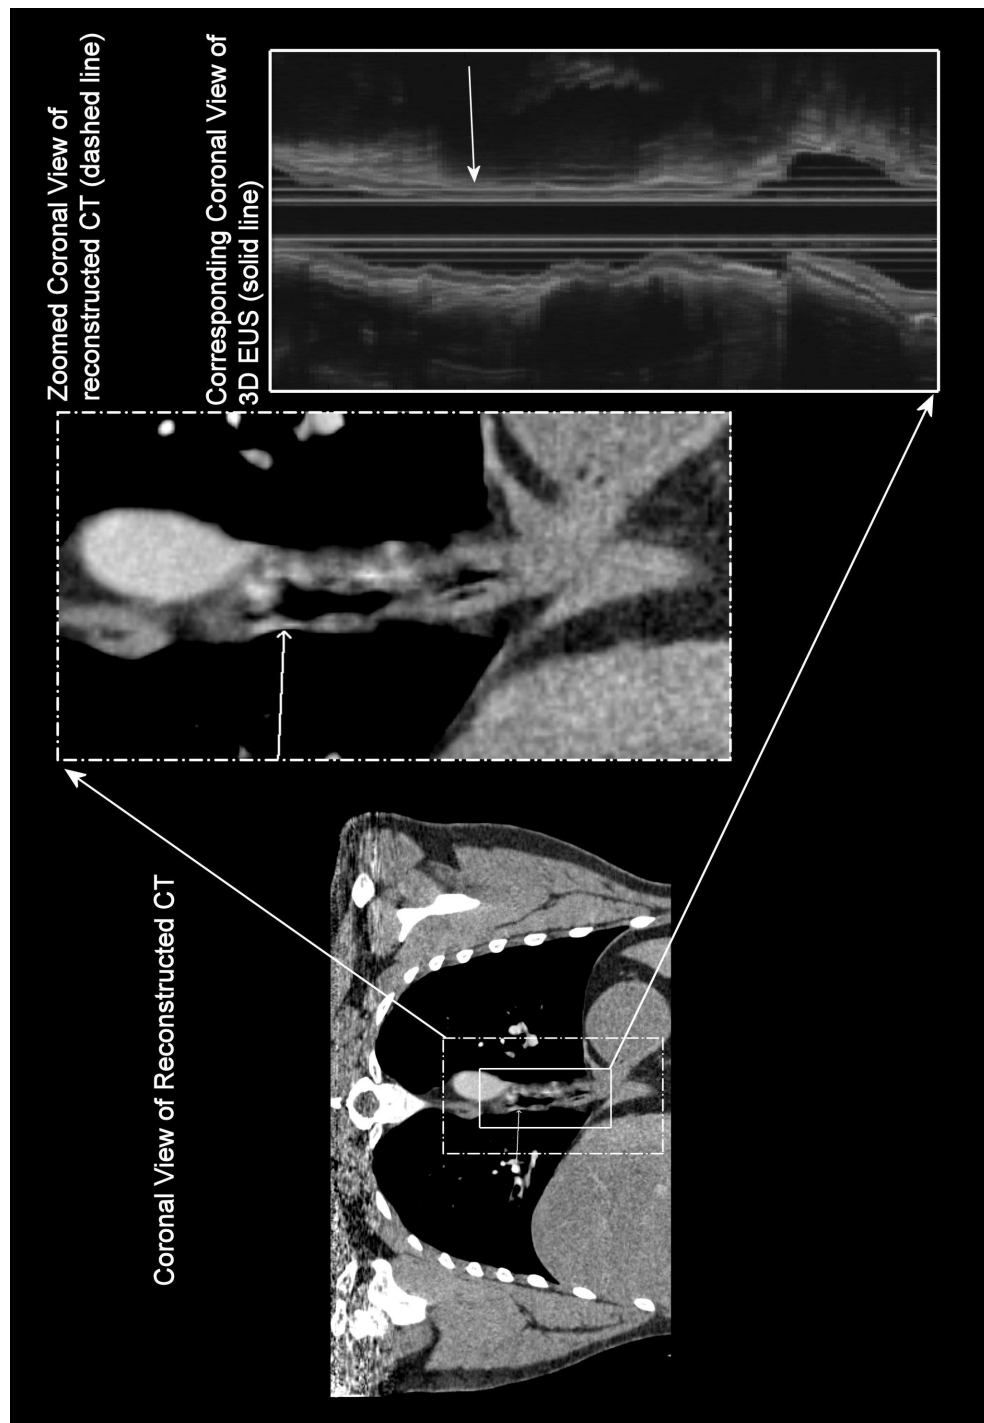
Comparison of coronal views between CT and 3D EUS, the coronal cuts of both CT and EUS. Due to the plane of cut, neither CT nor EUS showed any evidence of wall thickening.
